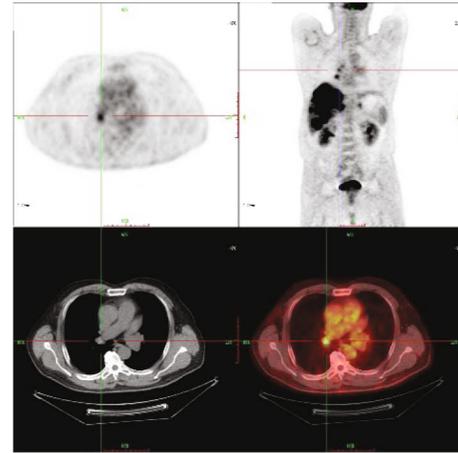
CT, PET, and PET/CT original images.
